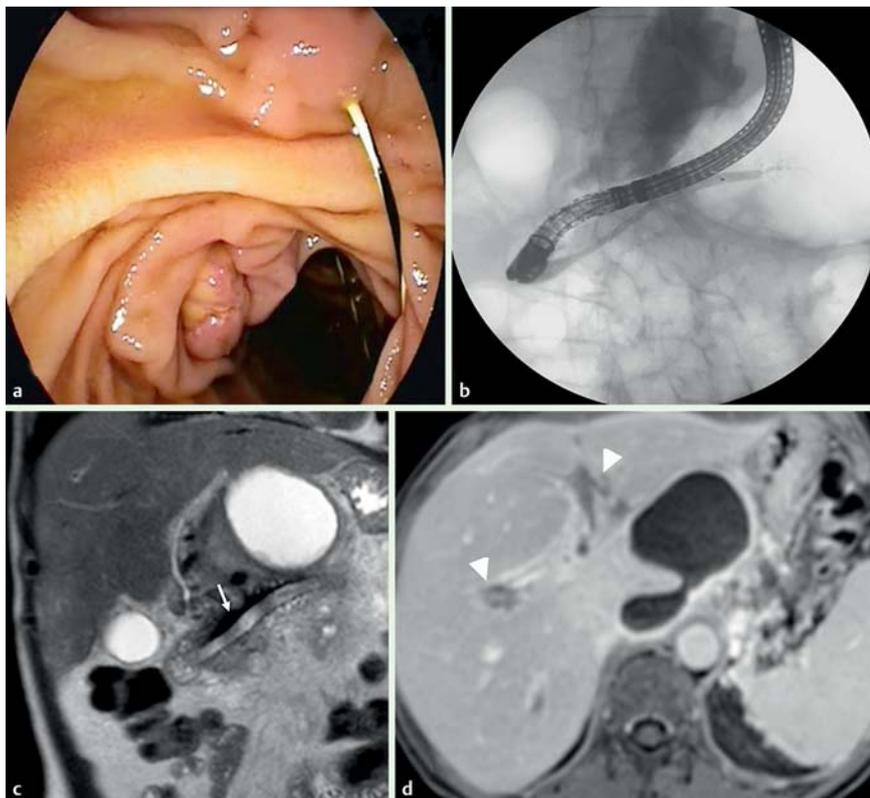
a Endoscopic view of the guidewire exiting the minor duodenal papilla. b Fluoroscopy shows insertion of the fully covered self-expanding metal stent (SEMS). c, d Follow-up magnetic resonance imaging (MRI) after 1 month shows the SEMS inside the main pancreatic duct (white arrow), and persistence of portal vein thrombosis but with a marked decrease in the caliber of the portal vein (arrowheads).
